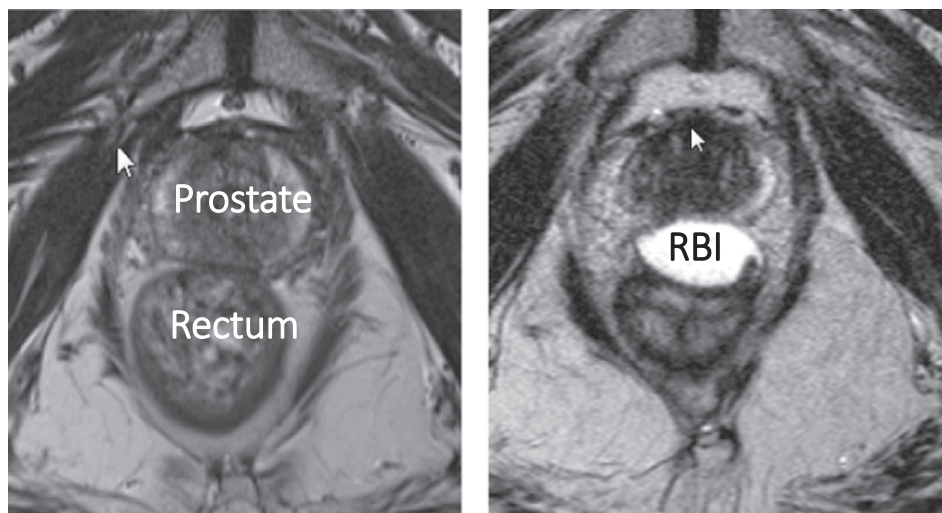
Axial T2-weighted MRI of a patient with an RBI before (a) and after implantation (b). Abbreviation: MRI = Magnetic Resonance Image; RBI = Rectal Balloon Implant.
